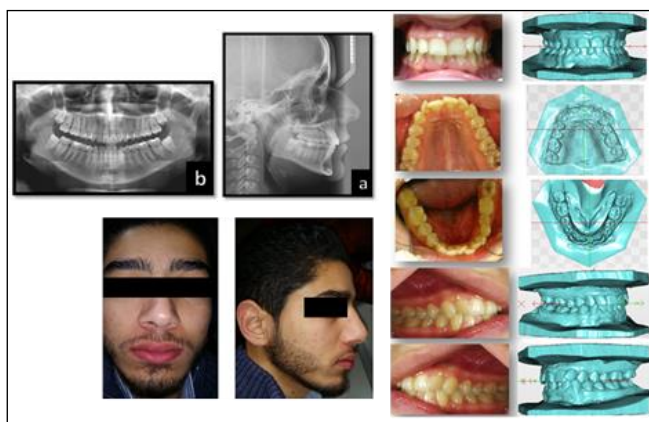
First patient: pre-treatment photographs and radiographs
